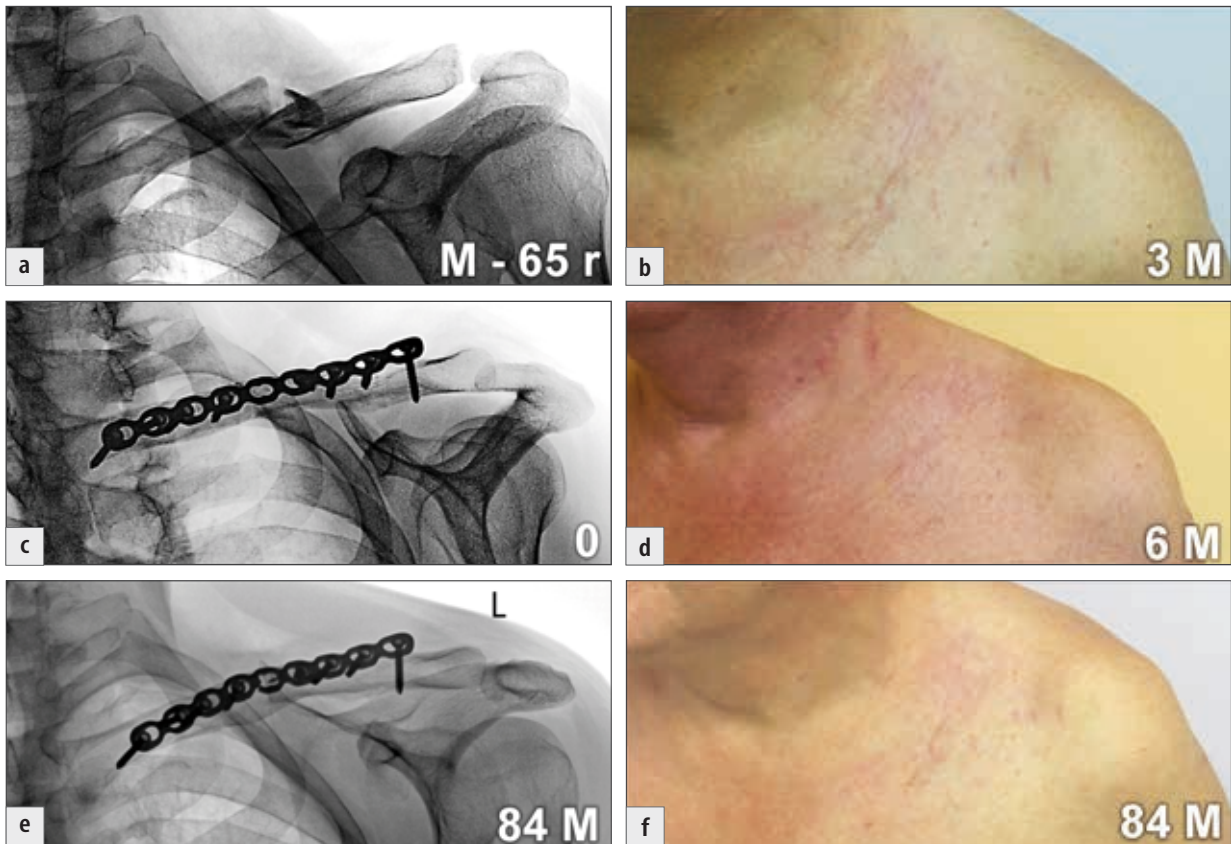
The course of bone union and the cosmetic effect of oblique incision, the patient from Fig. 17-22: a) preoperative radiograph; b) a scar 3 months after the operation; c) postoperative radiograph; d) a scar 6 months after the operation; e) radiograph 7 years after the operation, with the healed fracture; f) a scar 7 years after the operation.
